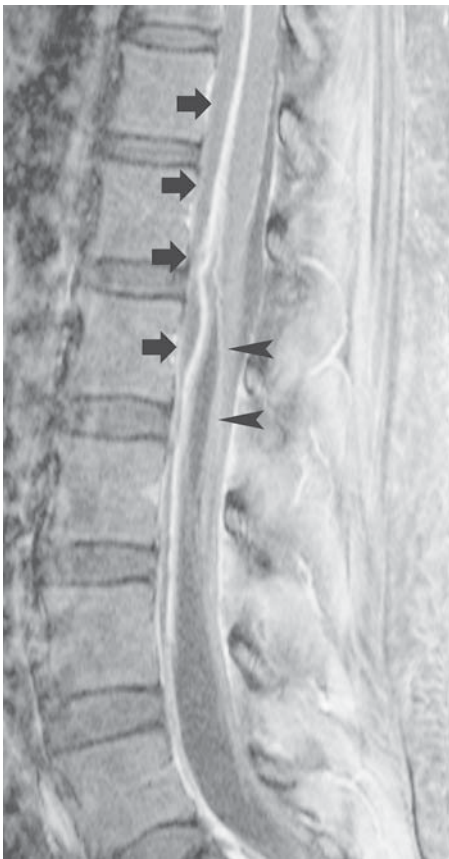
Epidural abscess and leptomeningitis. Sagittal postcontrast T1-weighted image reveals a peripherally enhancing ventral epidural abscess (*arrows*) with additional enhancing tissue surrounding the spinal cord and nerve roots.
